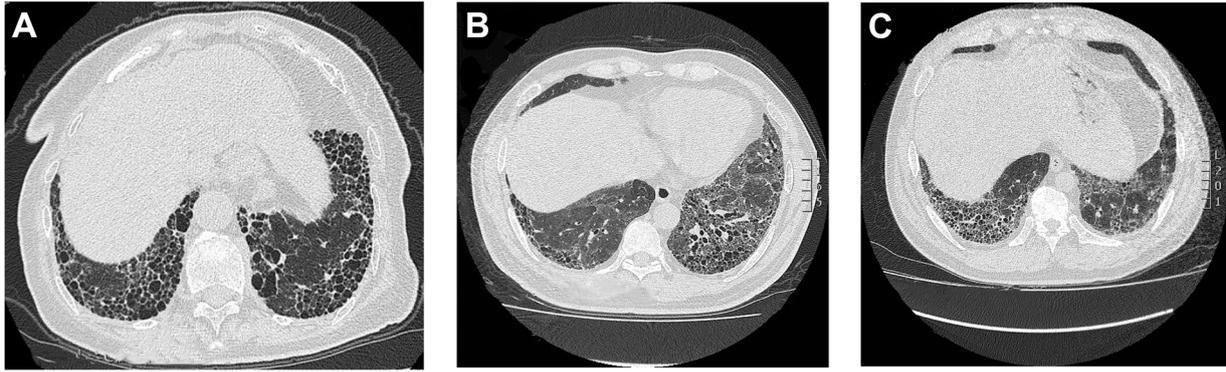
Chest computed tomography (CT) scans from patients with idiopathic pulmonary fibrosis (IPF). (A) A typical radiological pattern of usual interstitial pneumonia with subpleural honeycombing in the costophrenic angle in Patient A. Based on CT images from Patient B (B) and Patient C (C), there is a familial cluster of IPF in two brothers age 50 and age 52, respectively.
